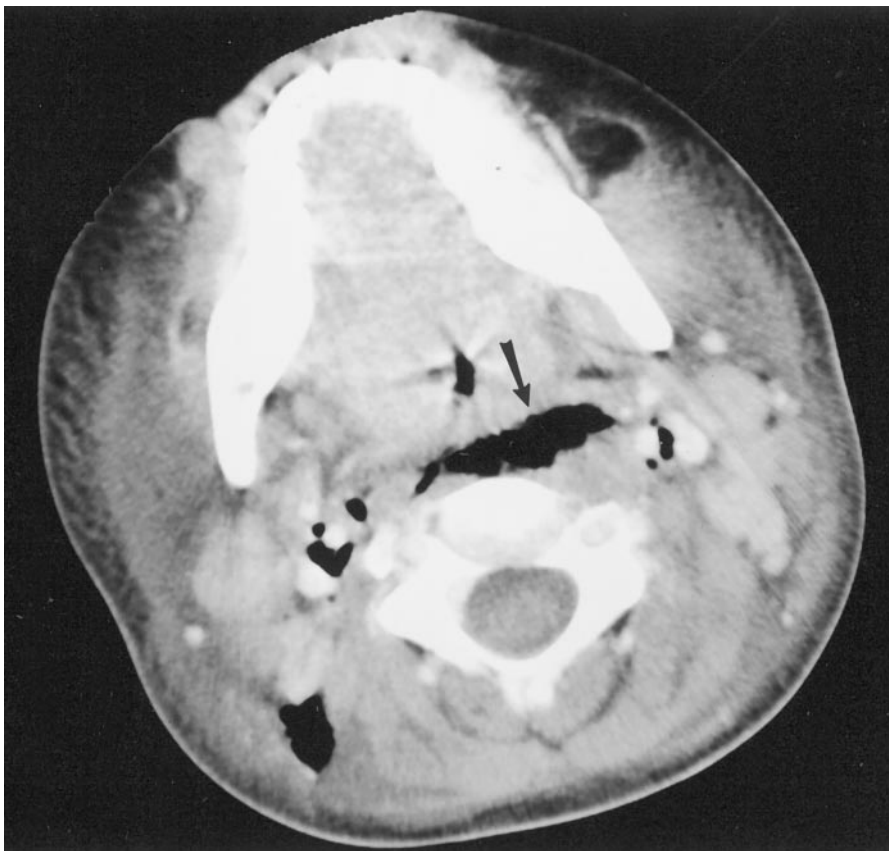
Axial CT scan showing extensive soft tissue swelling and subcutaneous emphysema in the retropharyngeal space (black arrow) and bilateral carotid sheaths.
